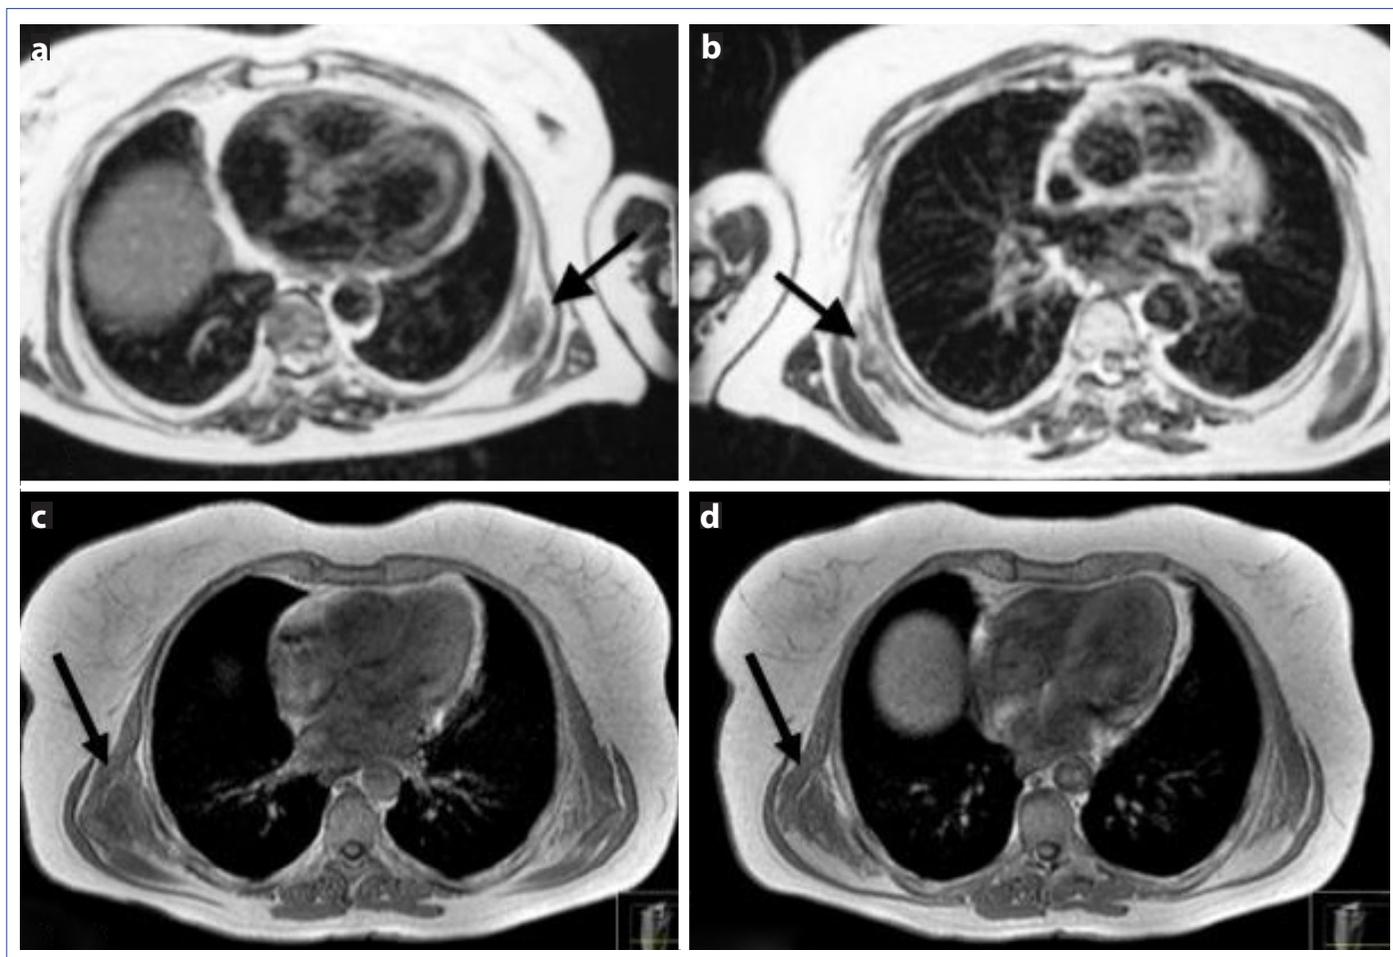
Thorax MRI (a, b) of bilaterally heterogeneous soft tissue masses and diffusion MR (c) of another case with right sided mass under latissimus dorsi.
